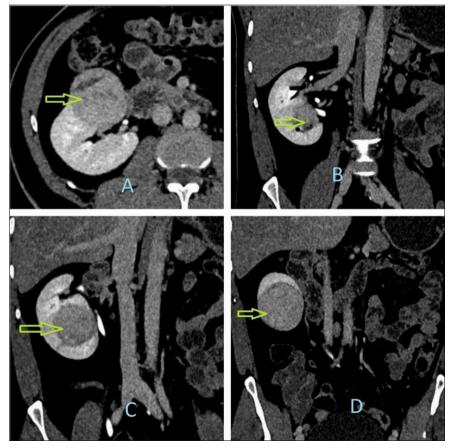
Contrast CT images of right kidney shows a well-defined, nearly spherical, iso- to hypodense, predominantly solid lesion (arrow) at the lower pole of right kidney with significant enhancement (>20 HU) on post-contrast images.
